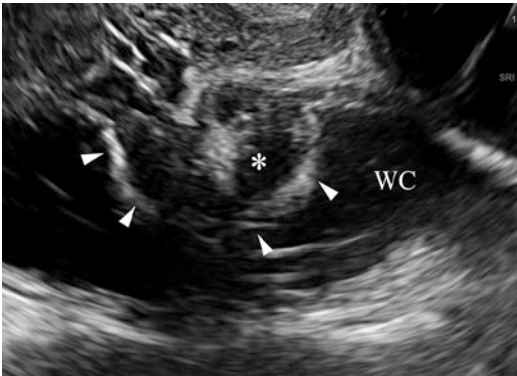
Rectal water contrast transvaginal ultrasonography shows a rectal endometriotic nodule (*asterisk*). The hyperechoic submucosa is not infiltrated (*arrowheads*). The rectum is dilated by saline solution (WC)
